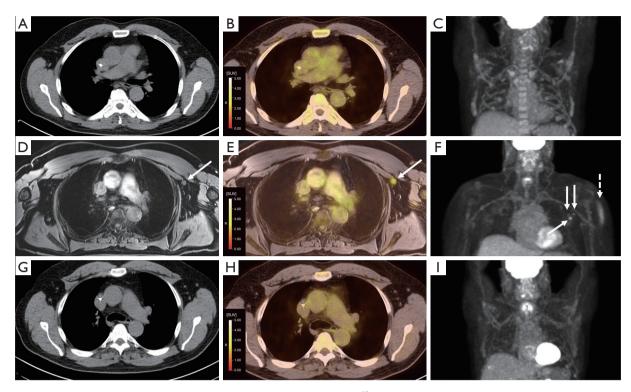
Patient 3: vaccine-related FDG-avid left axillary lymph nodes on ¹⁸FDG PET/MRI. Axial CT, fusion and MIP images from baseline (A-C, respectively), and follow-up ¹⁸FDG PET/MRI (D-F) & ¹⁸FDG PET/CT (G-I) studies. Baseline study demonstrates no abnormal or FDG-avid lymph nodes in the left axilla. Follow-up ¹⁸FDG PET/MRI 11 days after COVID-19 vaccination demonstrate faint FDG uptake in non-enlarged left axillary lymph nodes (white arrows) The largest measures 9 mm in short axis with an SUVmax of 3.45. Note also faint focal FDG activity in the left deltoid (dashed arrow) likely related to prior vaccination. These findings were managed conservatively with complete anatomic and metabolic response of lymph nodes on follow up ¹⁸FDG PET/CT two months later. MIP, maximum intensity projection; SUV, standardized uptake value.
